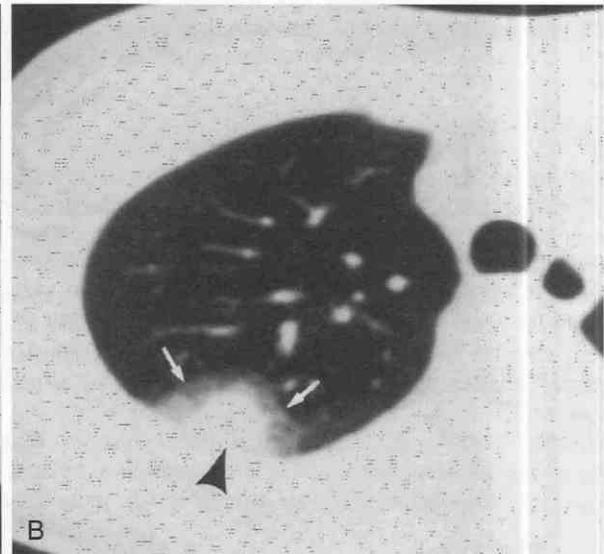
CT halo sign of invasive pulmonary aspergillosis. Three patients had acute myelogenous leukemia, prolonged aplasia owing to chemotherapy, and new-onset fever. In each case, an early focus of invasive pulmonary aspergillosis was identified with CT.
